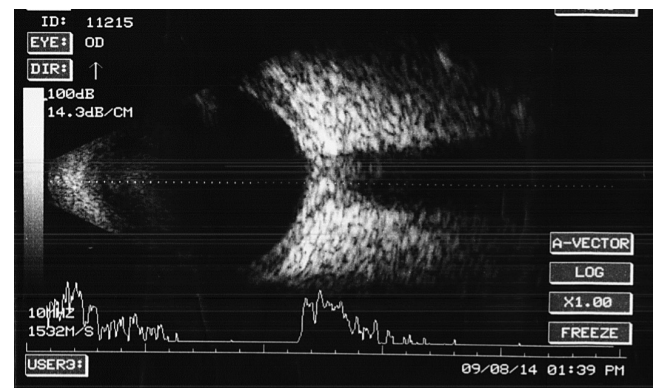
B-scan ultrasonography of the right eye shows chorioretinal thickening with classic T-sign, which represent subtenon fluid in patient with posterior scleritis.
